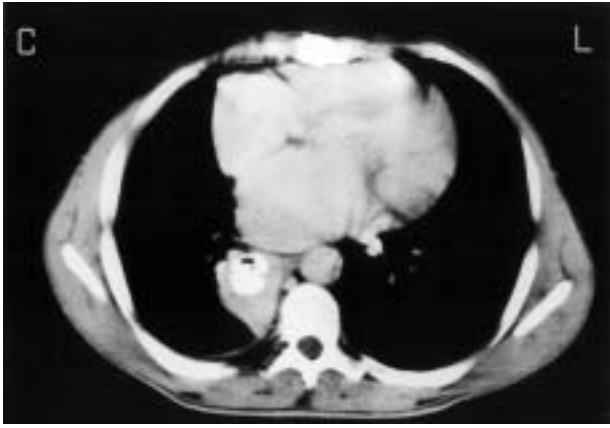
Computed tomography of the chest performed on admission.
